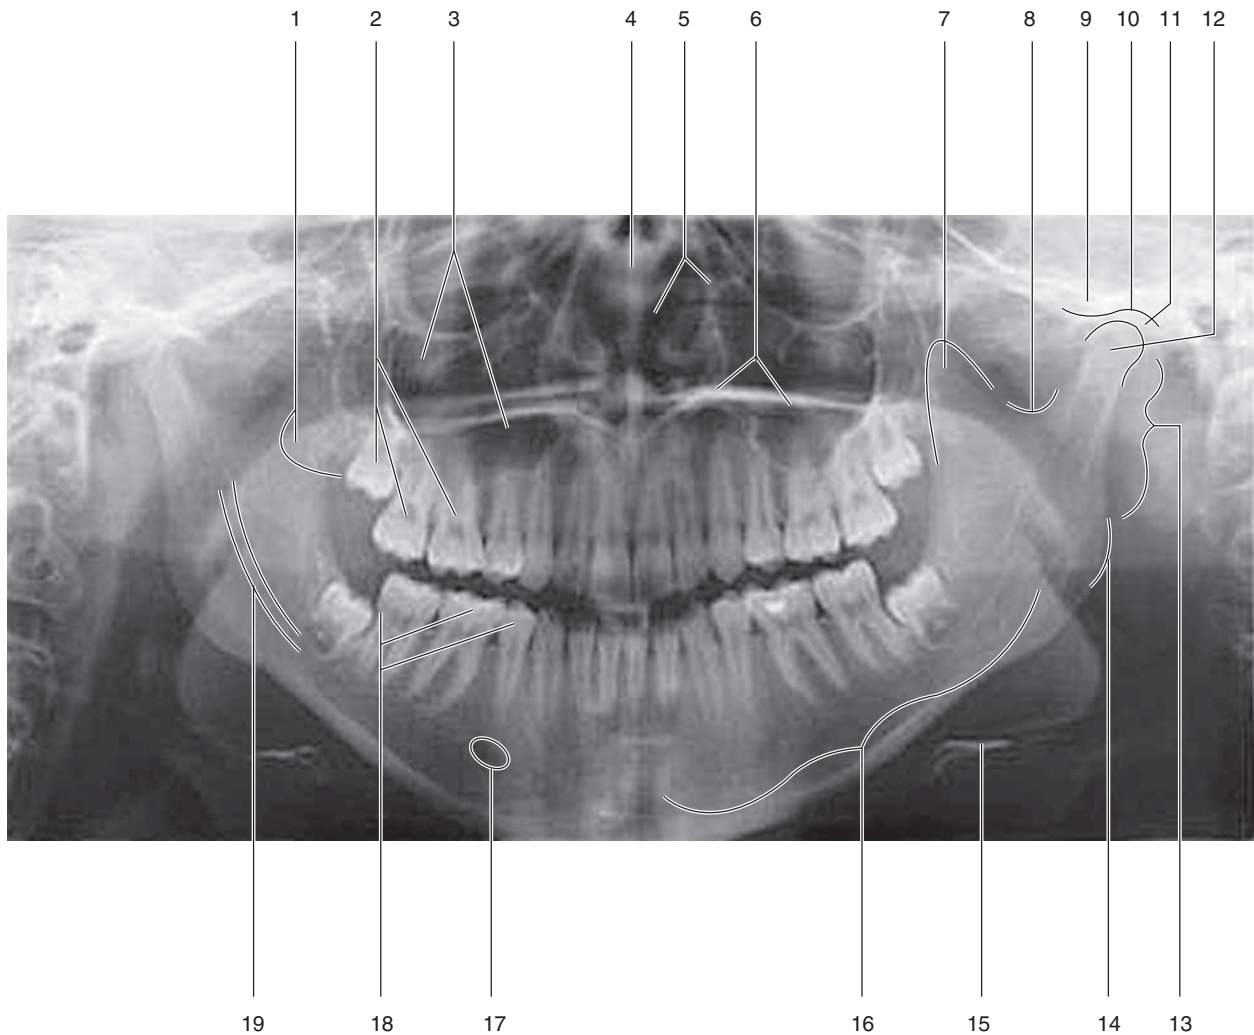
A panoramic radiograph (Panorex) shows many of the structures of the skull. Test your ability to identify these structure based on their shape and relative location by matching the letter of a description (A–S) with the number of each structure (1–19). (Radiograph courtesy of Dr. R. M. Jaynes, DDS, Assistant Professor at Ohio State University.)
